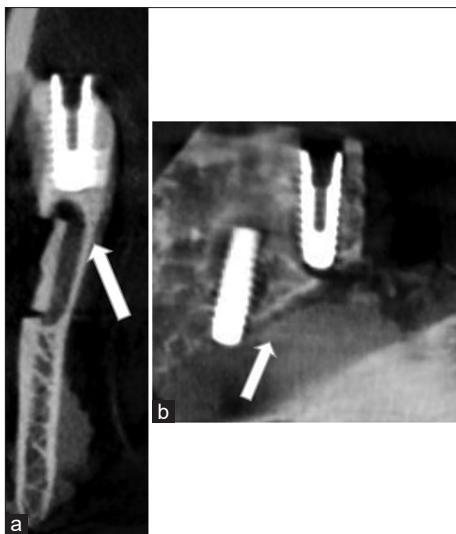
(a) Cross-sectional view of control implant, and (b) tangential cone-beam computed tomography views of implants with pilot drill injury to the inferior alveolar nerve canal (right implant) and penetration of the inferior alveolar nerve canal (left implant). Arrows point to inferior alveolar nerve canal.
